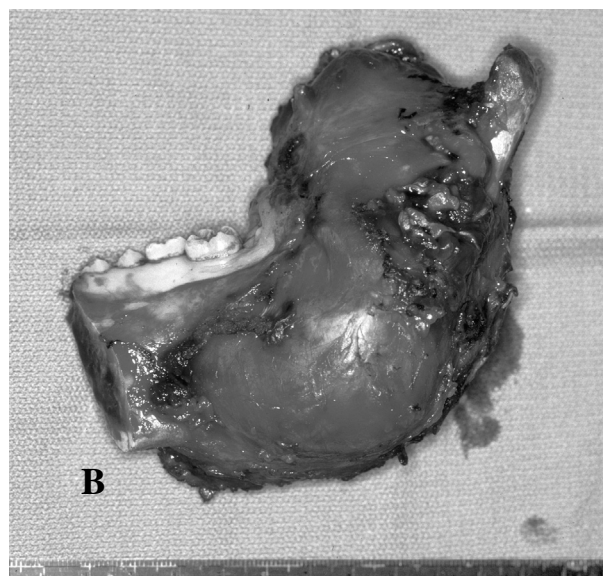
A unicystic ameloblastoma, mural subtype, of the mandible. A. CT scans show a destructive, expansile process of the right mandible. B. A disarticulation resection was required for curative therapy.
